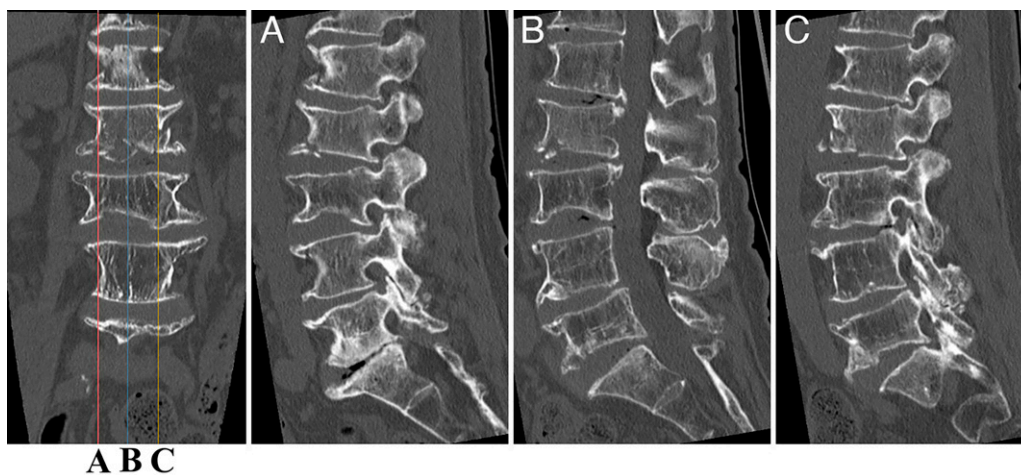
Preoperative CT. CT revealed a recent fracture of the L2 endplate.
